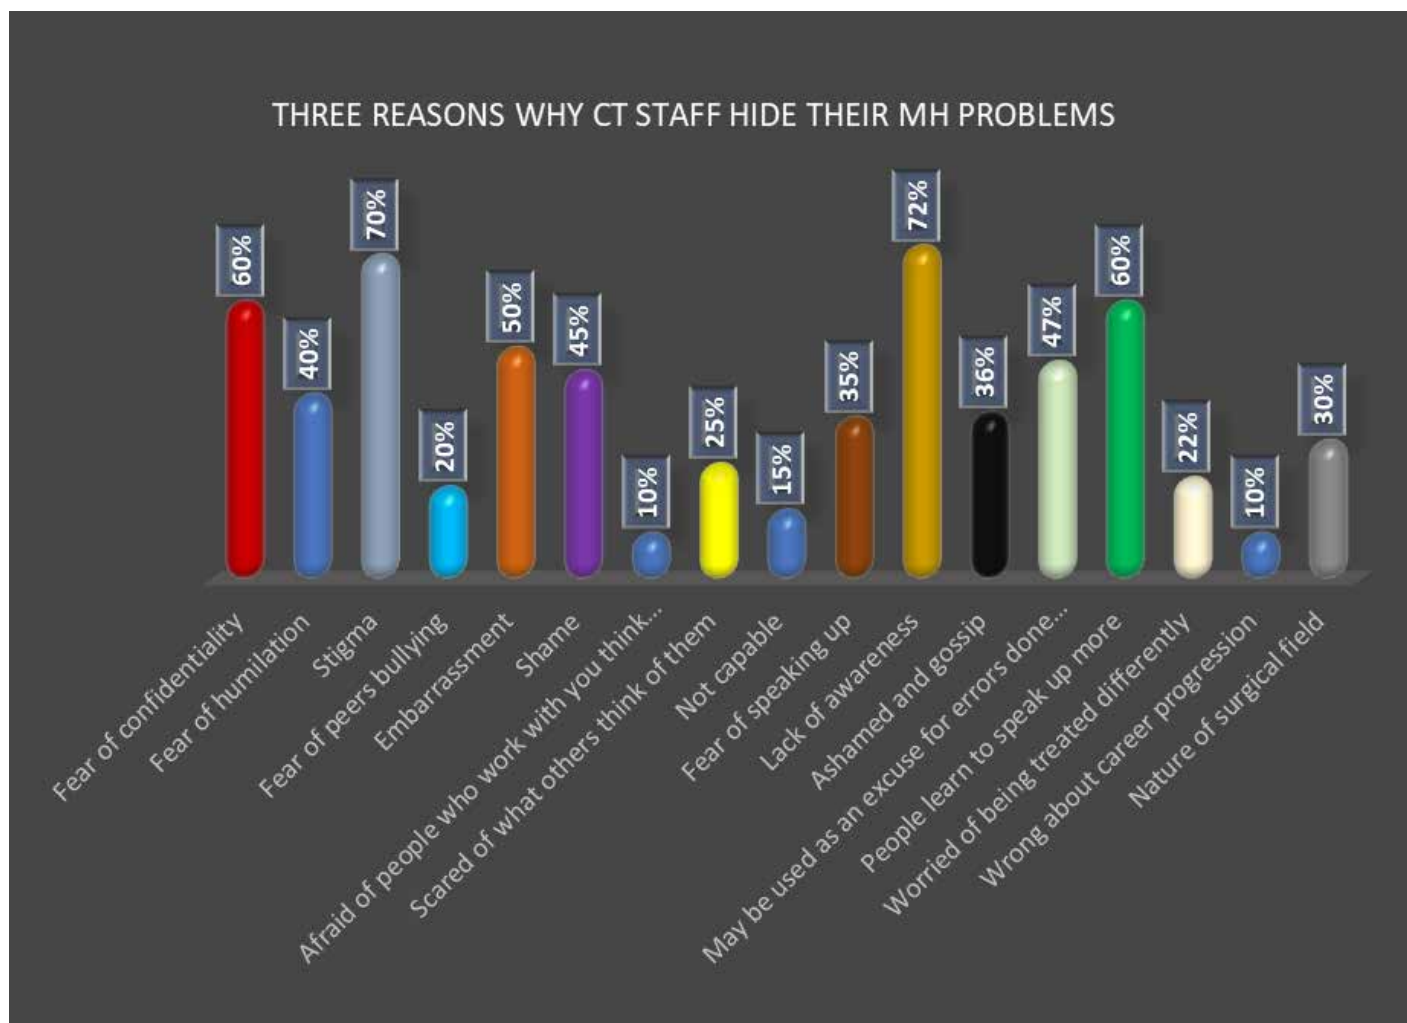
Three main reasons why CT hide their MH problems
